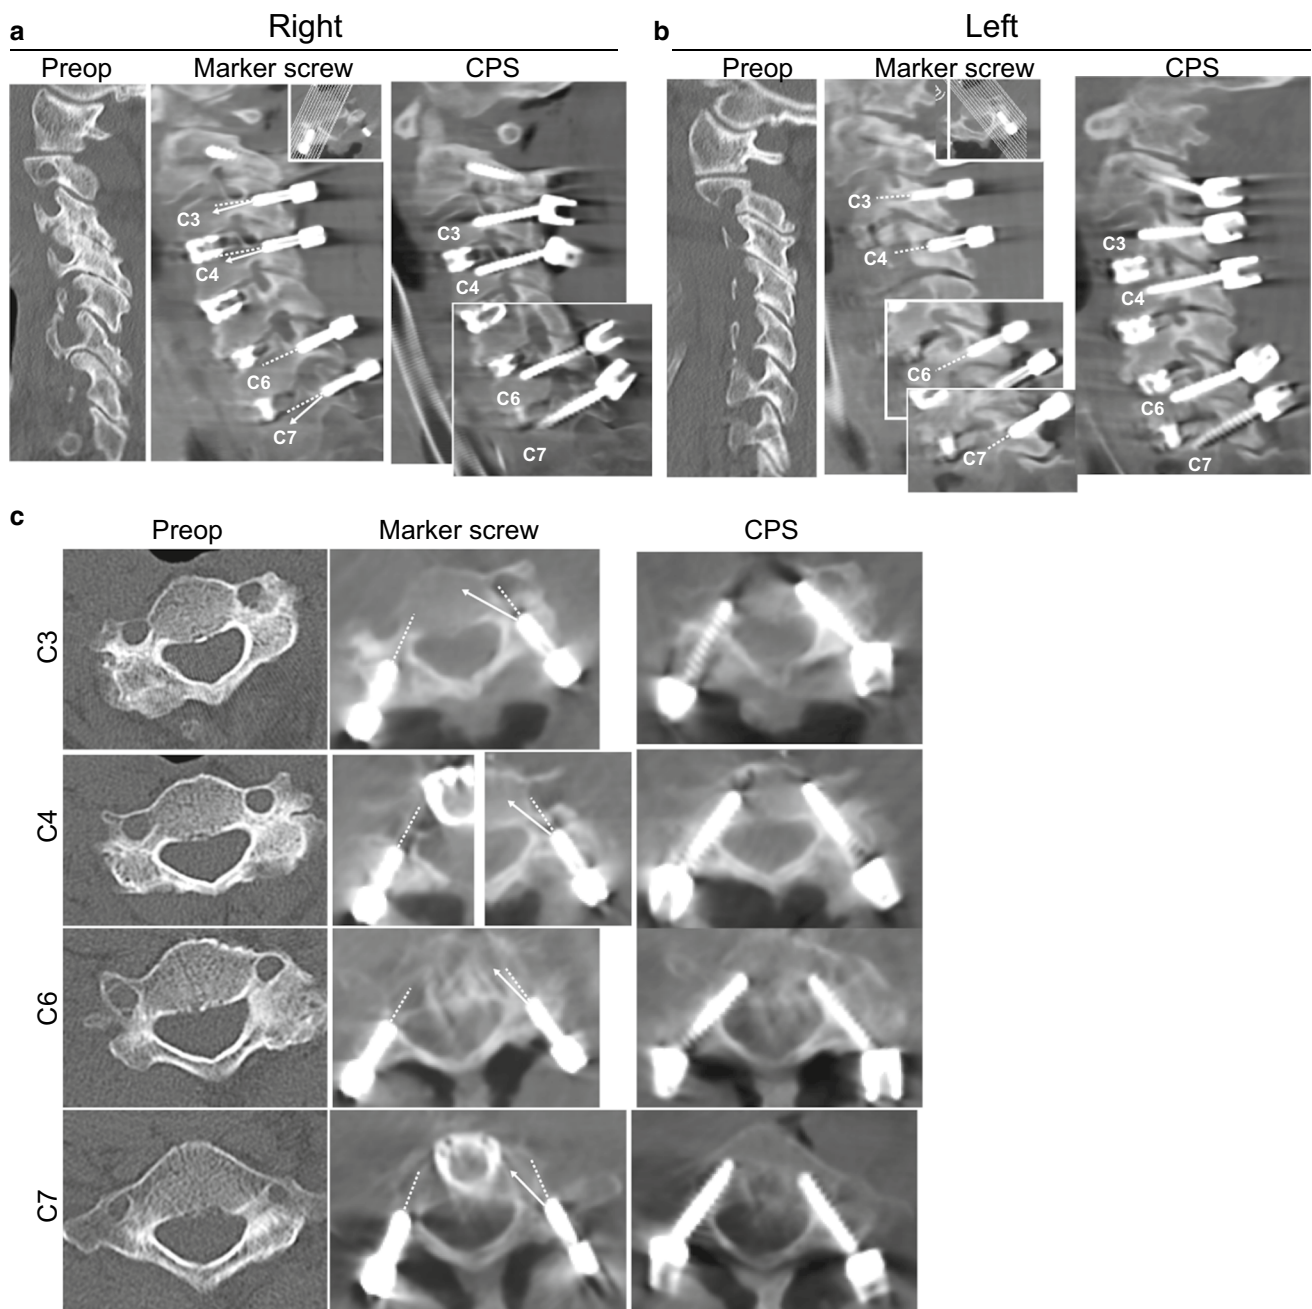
A 65-year-old woman with athetotic cerebral palsy developed cervical myelopathy caused by degenerative spondylolisthesis. She underwent combined anterior and posterior decompression and fusion using CPSs. Sagittal reconstruction CT-like images along right-side pedicles (a) left-side pedicles (b), and axial CT-like images at C3, C4, C6, and C7 are shown. Preoperative CT-like images show rotational deformity, facet joint degeneration as well as hyperostosis of lateral mass, which made CPS placement difficult. On the CT-like
